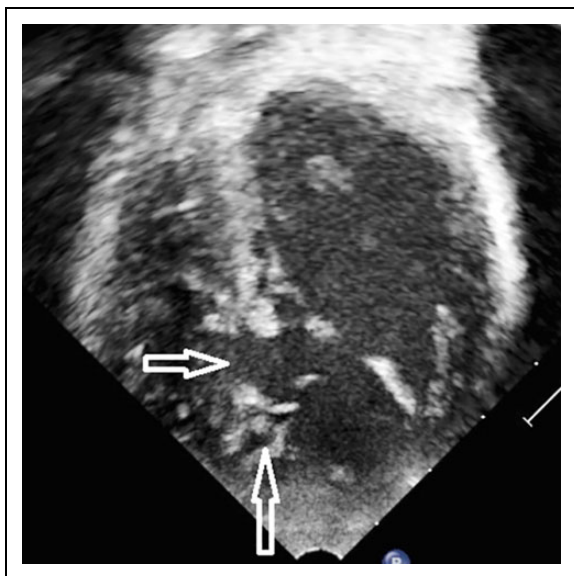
Echocardiography, modified apical four-chamber view: Anteriorly positioned muscular ventricular septal defect located apically in relation to the moderator band and measuring 8.5 mm (horizontal arrow) and small apical ventricular septal defect (vertical arrow).
